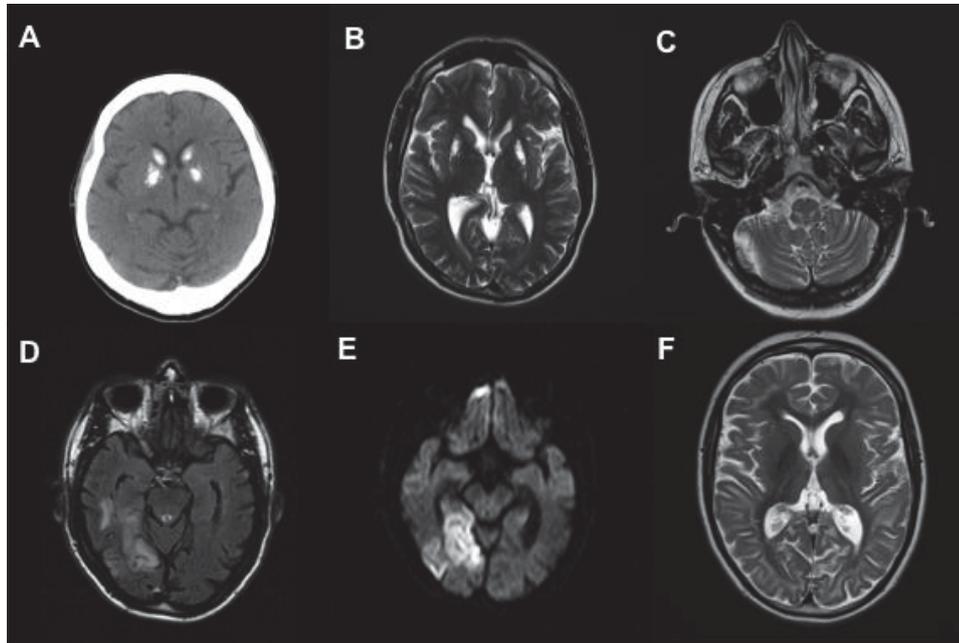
Radiological findings associated with mitochondrial disease. (A) CT head shows bilateral calcification in basal ganglia. (B) Axial T2-weighted MRI head shows symmetrical signal abnormalities in bilateral globus pallidi, typically seen in Leigh syndrome. (C) Axial T2-weighted MRI shows hyperintensities in the medulla in a young adult who presented with acute Leigh crisis. (D) FLAIR sequence of MRI head shows acute stroke-like lesions in the right temporal and occipital lobes of a patient who harbours the m.3243A>G mutation, corresponding with changes of restricted diffusion seen on DWI sequence (E). (F) Axial T2 weighted MRI shows diffuse white matter signal abnormalities identified in an adolescent with single, large-scale mtDNA deletion and Kearns-Sayre syndrome.
